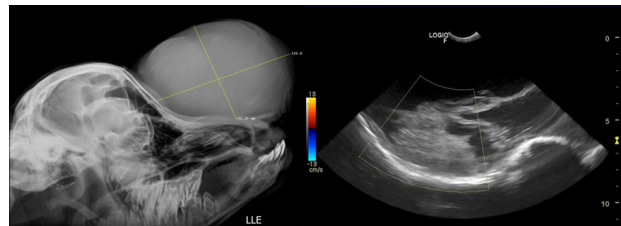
Complementary imaging examinations. A – Simple radiography of the skull in left latero-lateral projection, showing demarcation of the radiopaque region, with main axis measurements of approximately 12.6 and 9.2 cm. B – Doppler ultrasonography of the swelling in the region of the frontal bone of the skull. Green arrow – region of well-defined hypoechoic content. Red arrow – amorphous mass, with hyperechogenic delimitation without vascularization confirmed by Doppler.
